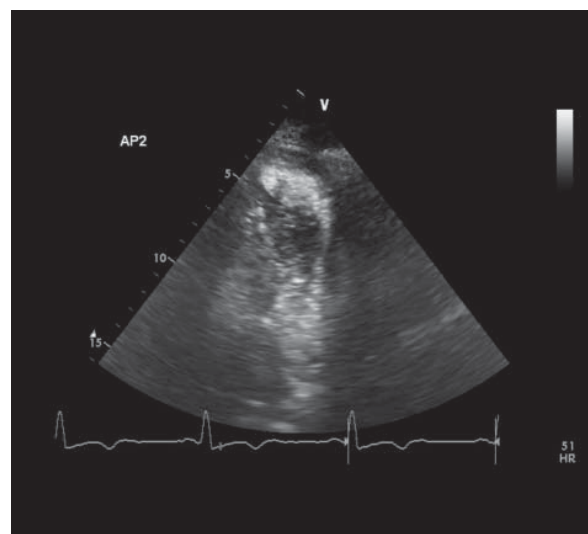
Transthoracic contrast echocardiogram shows the protruding, hypertrophic obstructive ring at the mid-apical segment of the left ventricle. The apical aneurysm "filled" in early systole and emptied in early diastole, with no flow during most of systole. The completely occlusive myocardial ring provoked systolic expansion at the apex.
